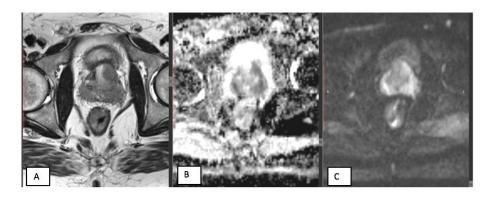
Figure ^{*}: A) axial & coronal T^γ, show multiple hypo-intense lesion seen at the peripheral zone basal segments at both sides as well as anterior segments at the left side. B&C) axial DWI/ADC shows marked restriction correlated with T^γ hypo-intensity.
